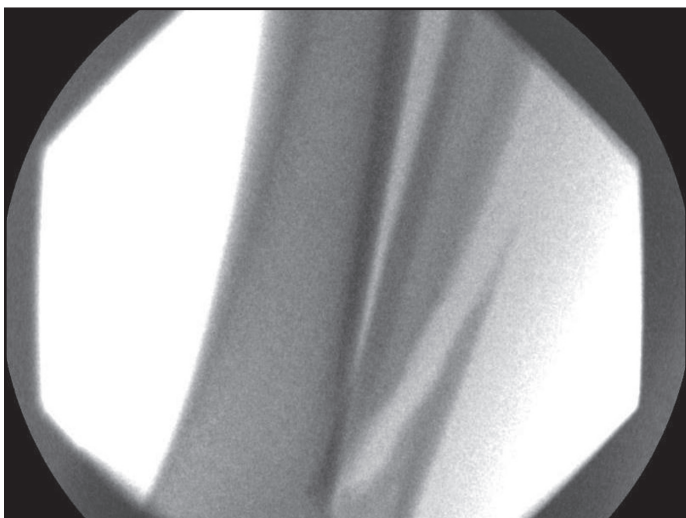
Radiograph showing distal oblique fracture of the fibula.
